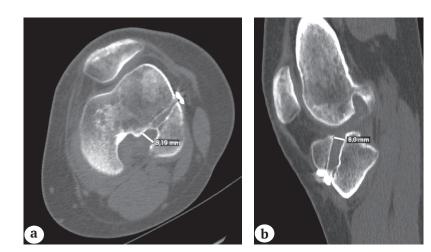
CT data: images of the bone tunnels: femoral (a) and tibial (b) in 6 months after surgery.
